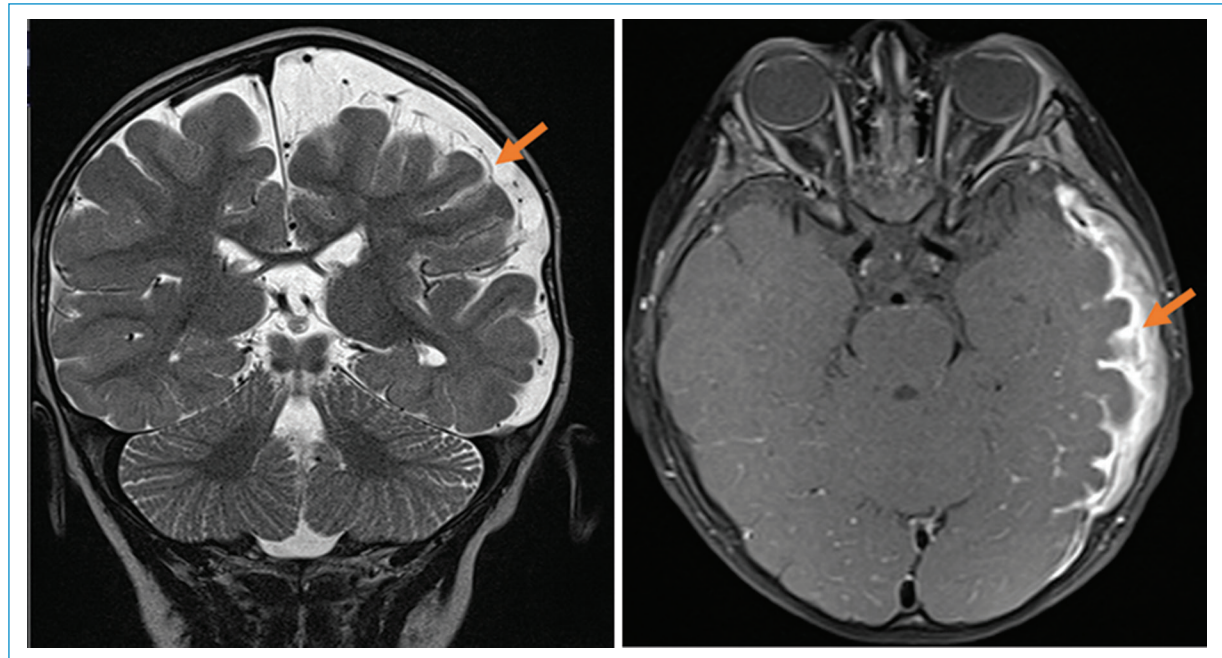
Coronal (left) and transverse (right) plane of MRI images with left cerebral atrophy, involving the frontoparietal and temporal regions. Marked leptomeningeal enhancement compatible with leptomeningeal angiomatosis (see arrow).
